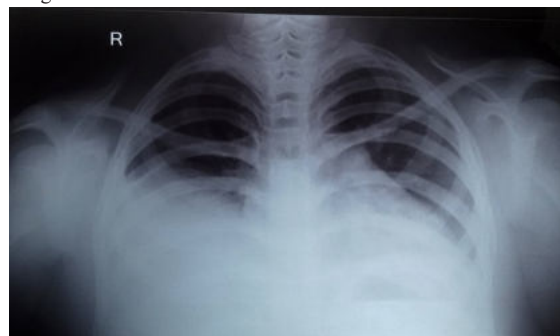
Antero posterior radiograph showing homogenous opacity in right mid and lower zone
